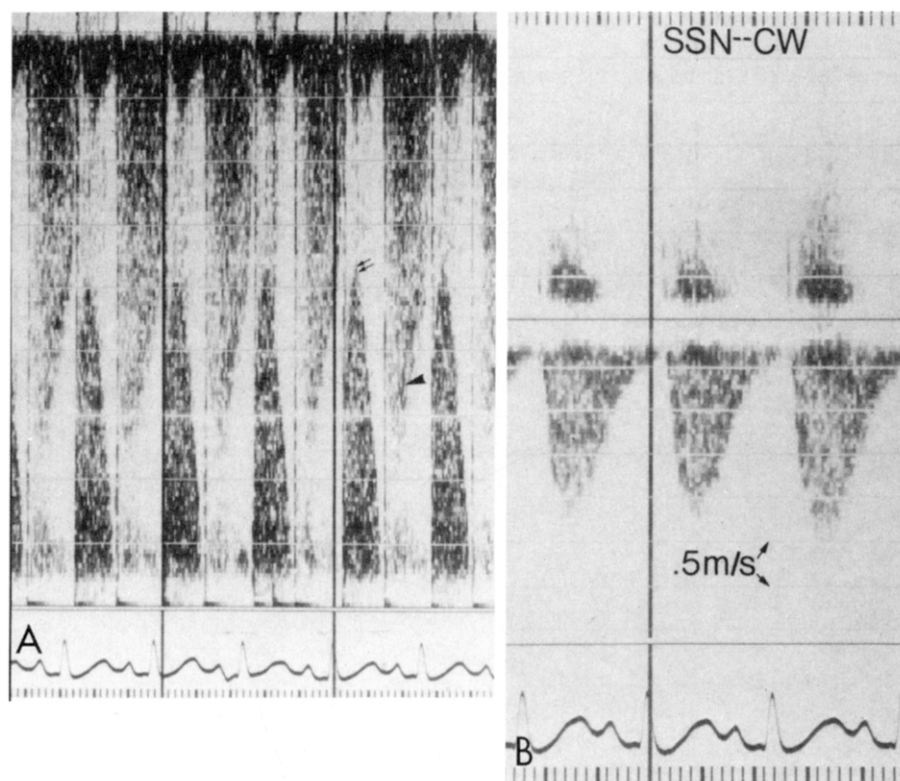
Continuous wave (CW) Doppler recordings obtained from the supra-sternal notch (SSN). A, Ascending aorta, 18th hospital day. In systole, a jet (small arrow) is recorded above the baseline indicating flow toward the transducer from the left ventricle to the ascending aorta. The peak velocity of the jet is 2.7 m/s, indicating a 30 mm Hg pressure gradient across the aortic valve. In diastole, a high velocity jet (large arrow) is seen below the baseline, indicating regurgitant flow from the aorta to the left ventricle. As assessed by the pulsed Doppler system and a mapping technique, the amount of aortic insufficiency had increased dramatically since the initial studies. The Doppler recording is displayed with a zero shift baseline and calibration lines at 0.5 m/s intervals. B, Descending aorta, 18th hospital day. A 2.5 m/s jet (25 mm Hg predicted pressure gradient) is recorded in the descending aorta. The continuous flow signals throughout systole and diastole are characteristic of an aortic obstruction.
